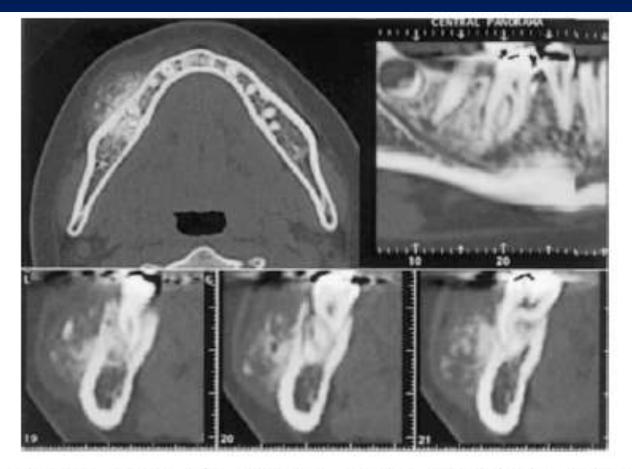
Above left: axial CT showing mixed-density lesion surrounding the roots of 46 (right lower first molar) with buccal expansion. However the buccal cortex is intact. Above right and below: MPR showing extensions to the tumour into the bone marrow by way of the periodontal ligament
